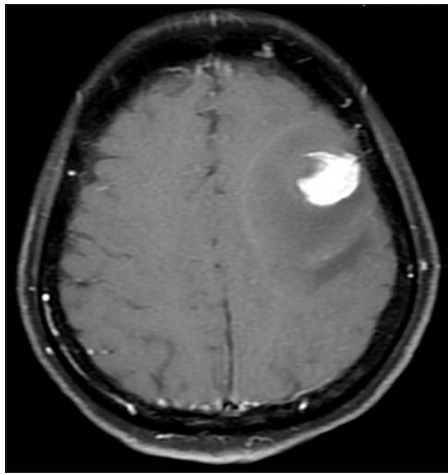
Contrast-enhanced brain magnetic resonance imaging reveals a 2 cm enhancing lesion in the left frontal lobe with perifocal edema
